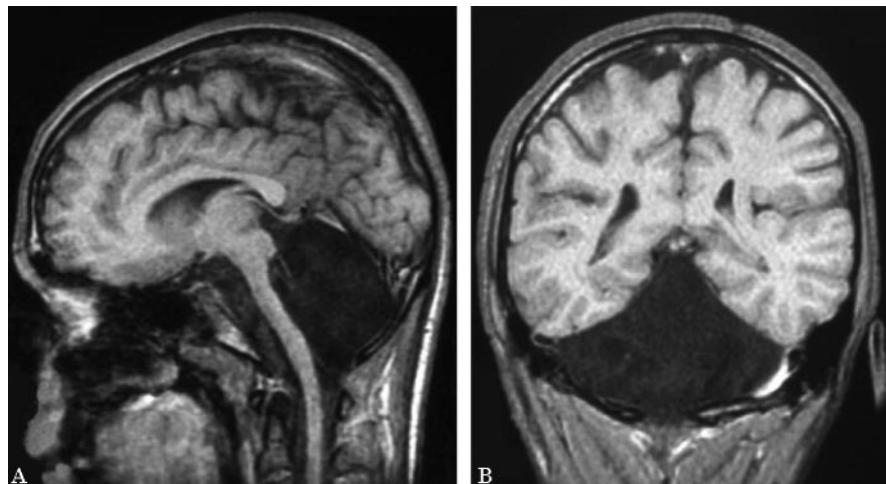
weighted sagittal (A) and coronal (B) brain MRIs showing total cerebellar agenesis.
